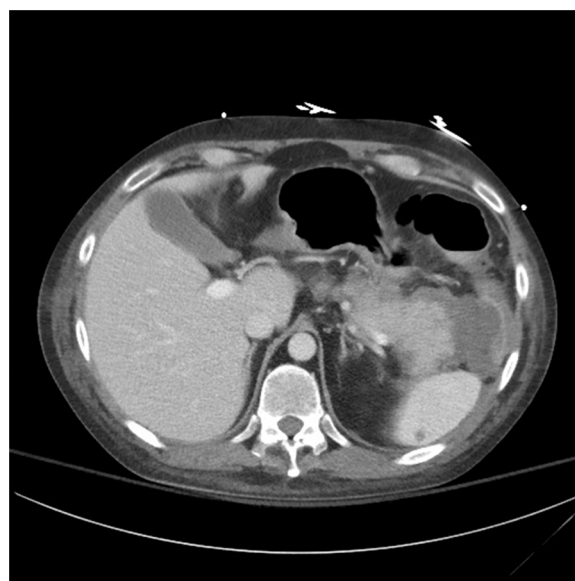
CT abdomen on hospital day 20, showing worsening pancreatic collection.
